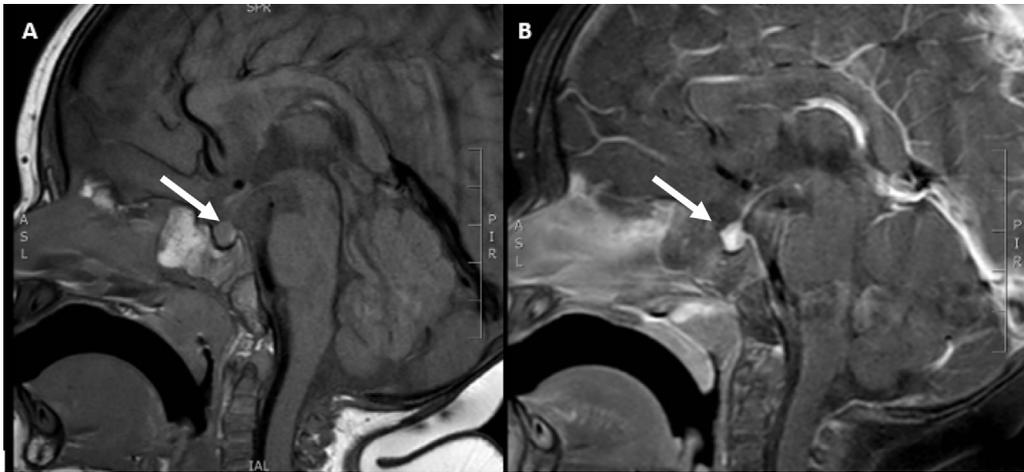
Magnetic resonance imaging at age 12 months. T1 noncontrast (A) and T1 postcontrast (B) with arrows showing decreased size of the sellar and suprasellar mass with persistent enhancement.
